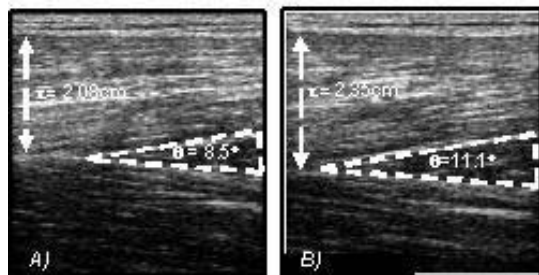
Typical sonographs of the sagittal plane of the vastus lateralis muscle at rest, with the knee at an angle of 85Deg (right angle is 90Deg). A) AM and B) PM, showing pennation angle (theta) and muscle thickness (t).
